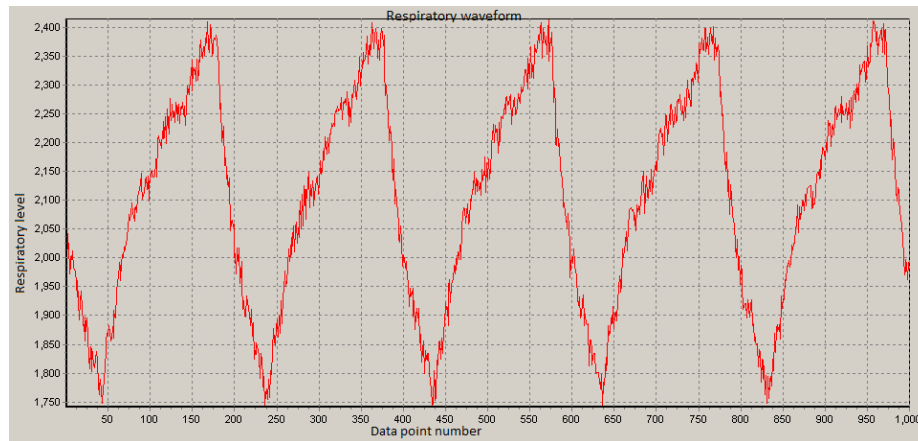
A section of the respiratory waveform data from the CT non-image DICOM file. The values on the axes are nominal units of data number and level.
